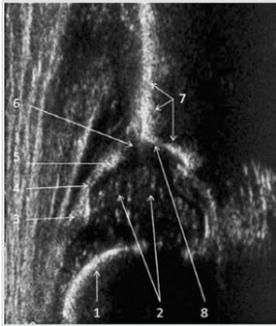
Standard sonogram and Graf checklist [3] (Figure 3, with the permission of Medical Ultrasonography Journal 2013, Vol. 15, no. 4, 299-303).
